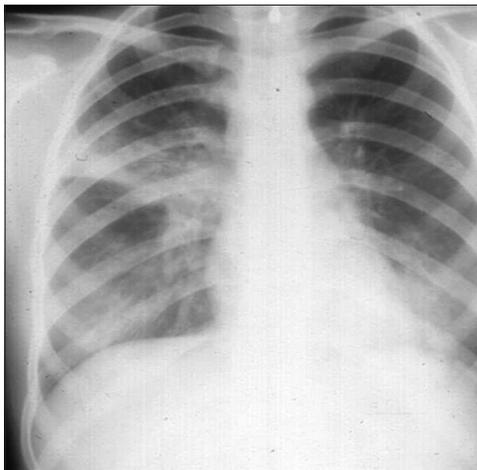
Chest X-ray of Case number 2.
